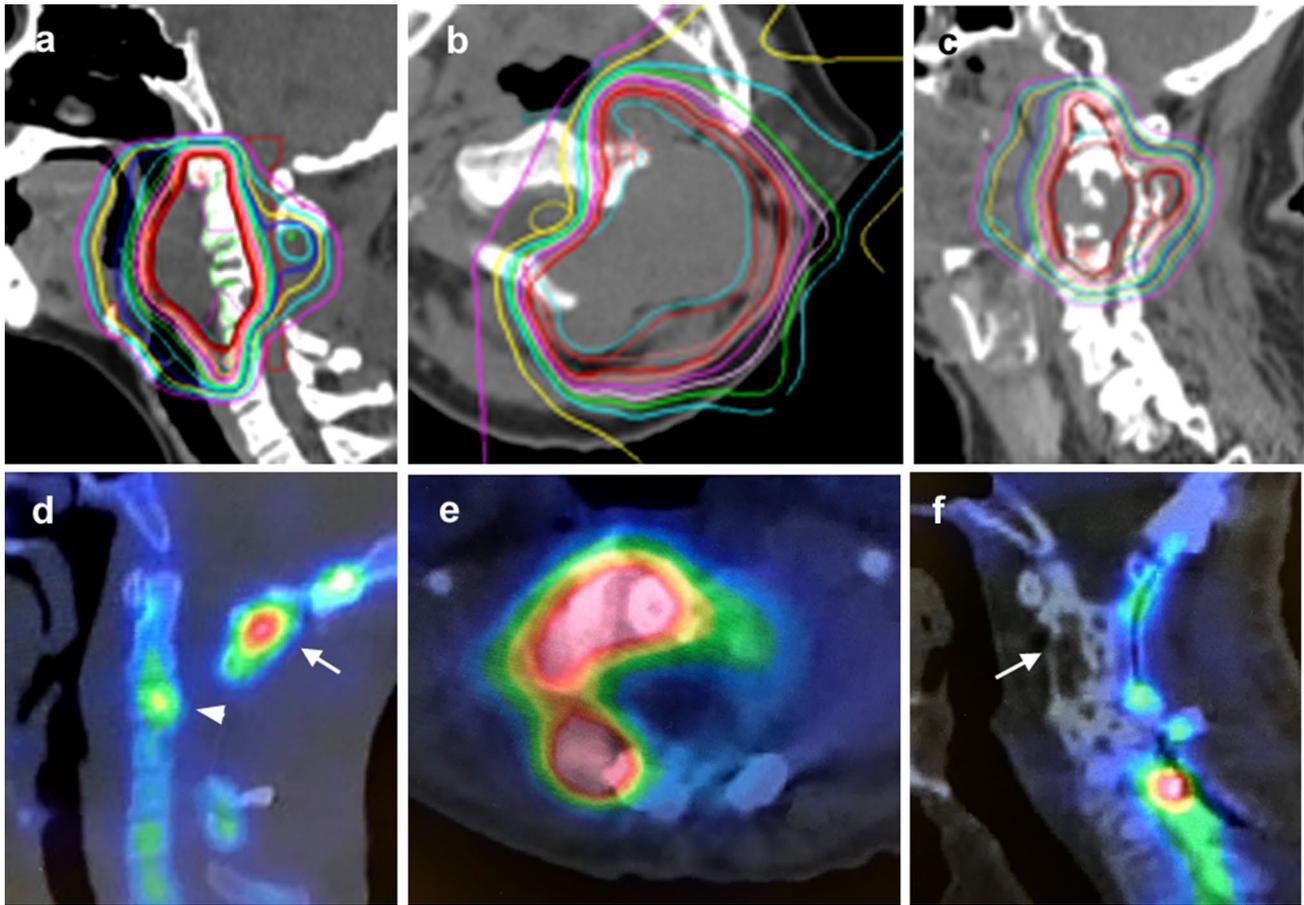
The dose distribution (a–c) and bone SPECT/CT (d–f) for each case to evaluate the effect of CIRT on bone turnover. The red line indicates 90% isodose of the prescribed dose. a, d In Case 1, the active bone formation was confirmed in the autograft and surrounding bone (d arrow). Remarkably, the collapsed vertebra (C3) showed
